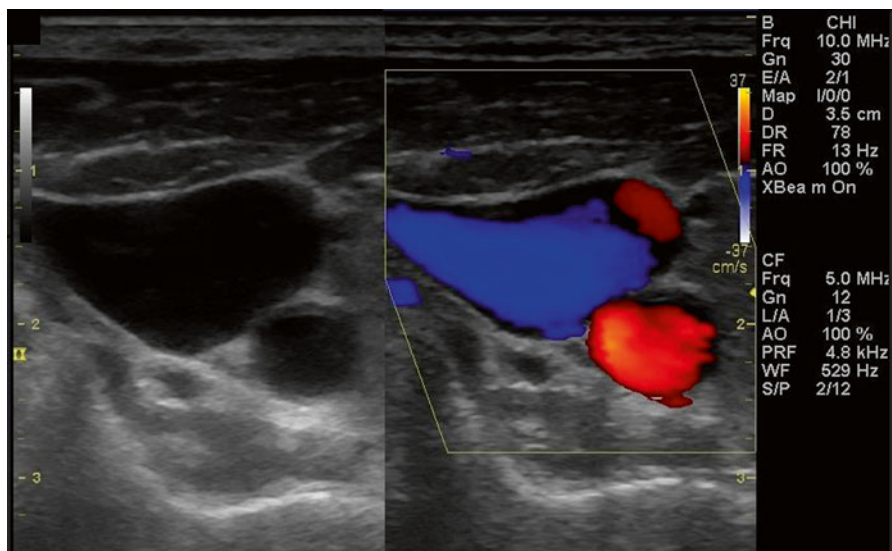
Showing the transverse view of the right common carotid artery and the right internal jugular vein with B-mode display on the left side and the color Doppler mode on the *right*. Observe the legend on the *right* showing red above and *blue* below. Also, note the parameters of the B-mode and color Doppler (CF) mode. In this image the B-mode has a frequency of 10.0 MHz and the CF (Color Flow) Doppler mode has a frequency of 5.0 MHz
